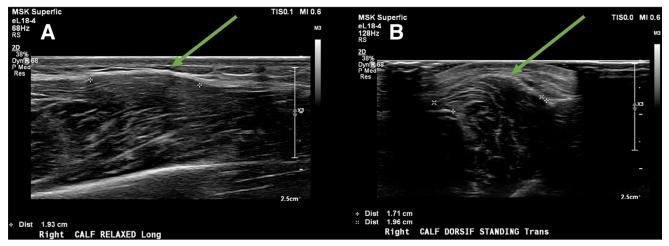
Dynamic ultrasound of a right lower leg demonstrating a fascial defect (green arrow) at rest without evidence of herniation (A) and muscle herniation through the fascial defect with active patient ankle dorsiflexion (B).
